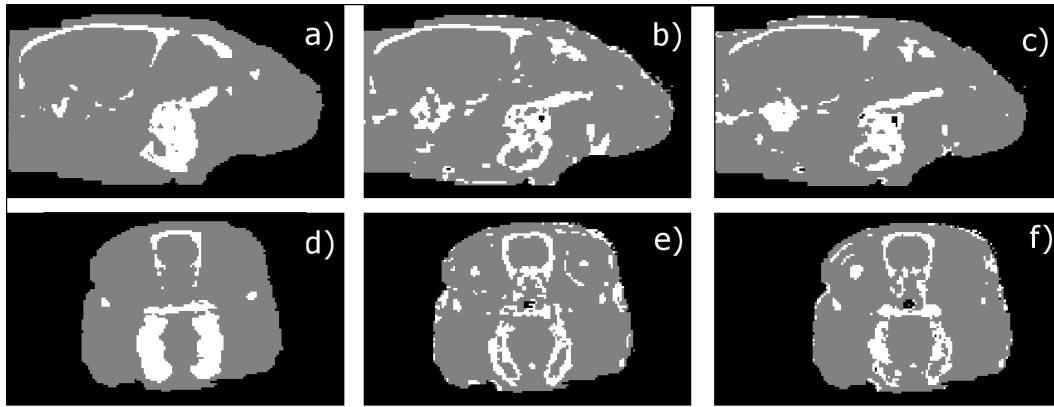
Segmented images in three tissue classes; air (black), bone (white) and soft tissue (gray). Coronal and sagittal view of CT (a,d), UTE1-UTE2(b,e) and T1-UTE1-T2(c,f) respectively.
